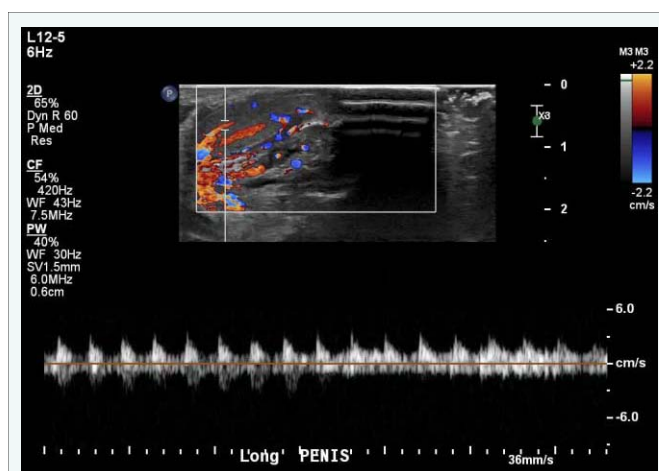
Penile duplex ultrasound (long axis) from Case 2 demonstrating normal penile (arterial) blood flow.
